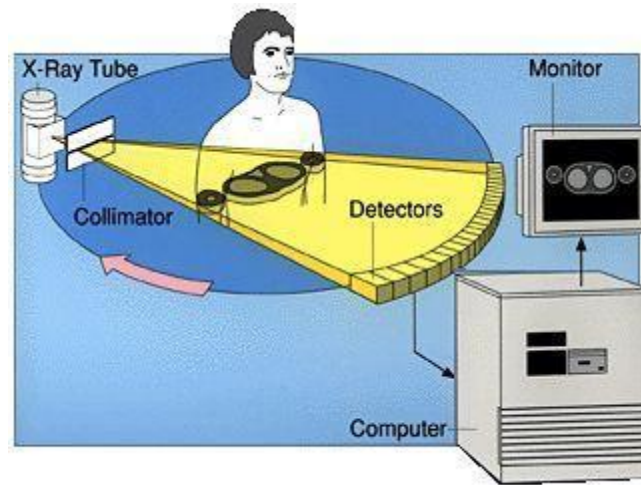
CT Imaging Basic Process. [18]
